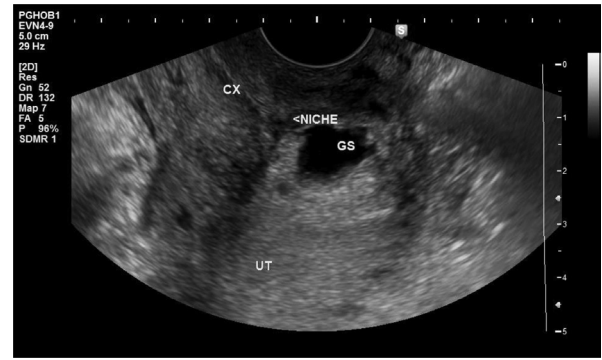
A magnified transvaginal sagittal ultrasound scan showing the cervix (CX) with an empty endocervical canal. The gestational sac (GS) is located above the internal cervical os at the anterior lower uterine segment and within the cesarean section niche
